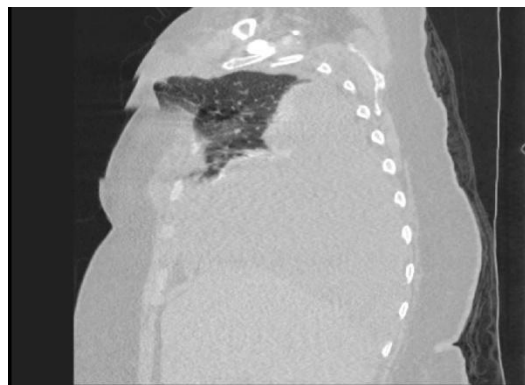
CT Scan of Thoracic Pulmonary Herniation
